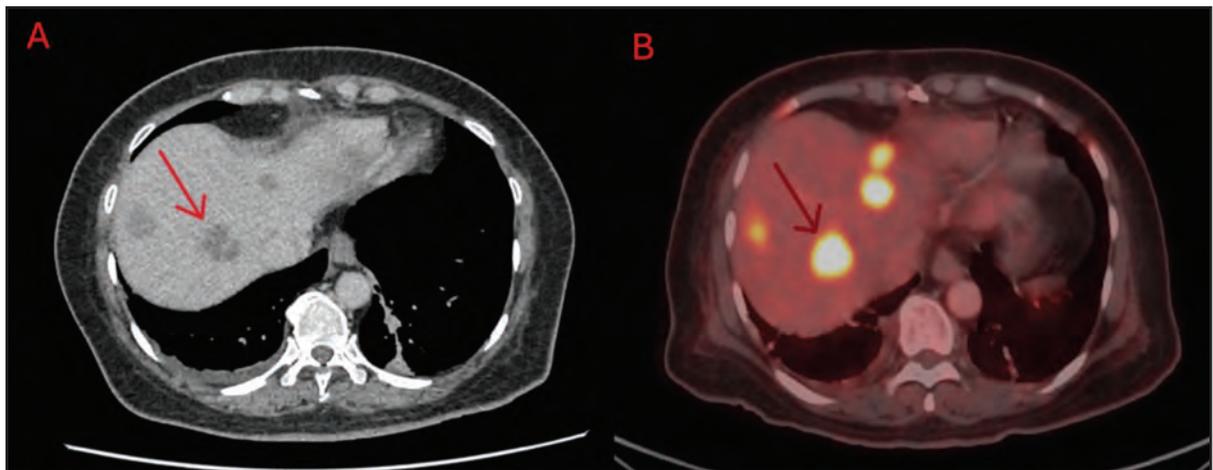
Imaging Finding for Case 3: (A) Transaxial CT image showing multiple hypodense lesions in the liver (red arrow); (B) Corresponding PET/CT fusion image demonstrating diffusely increased FDG uptake in the liver (red arrow)
